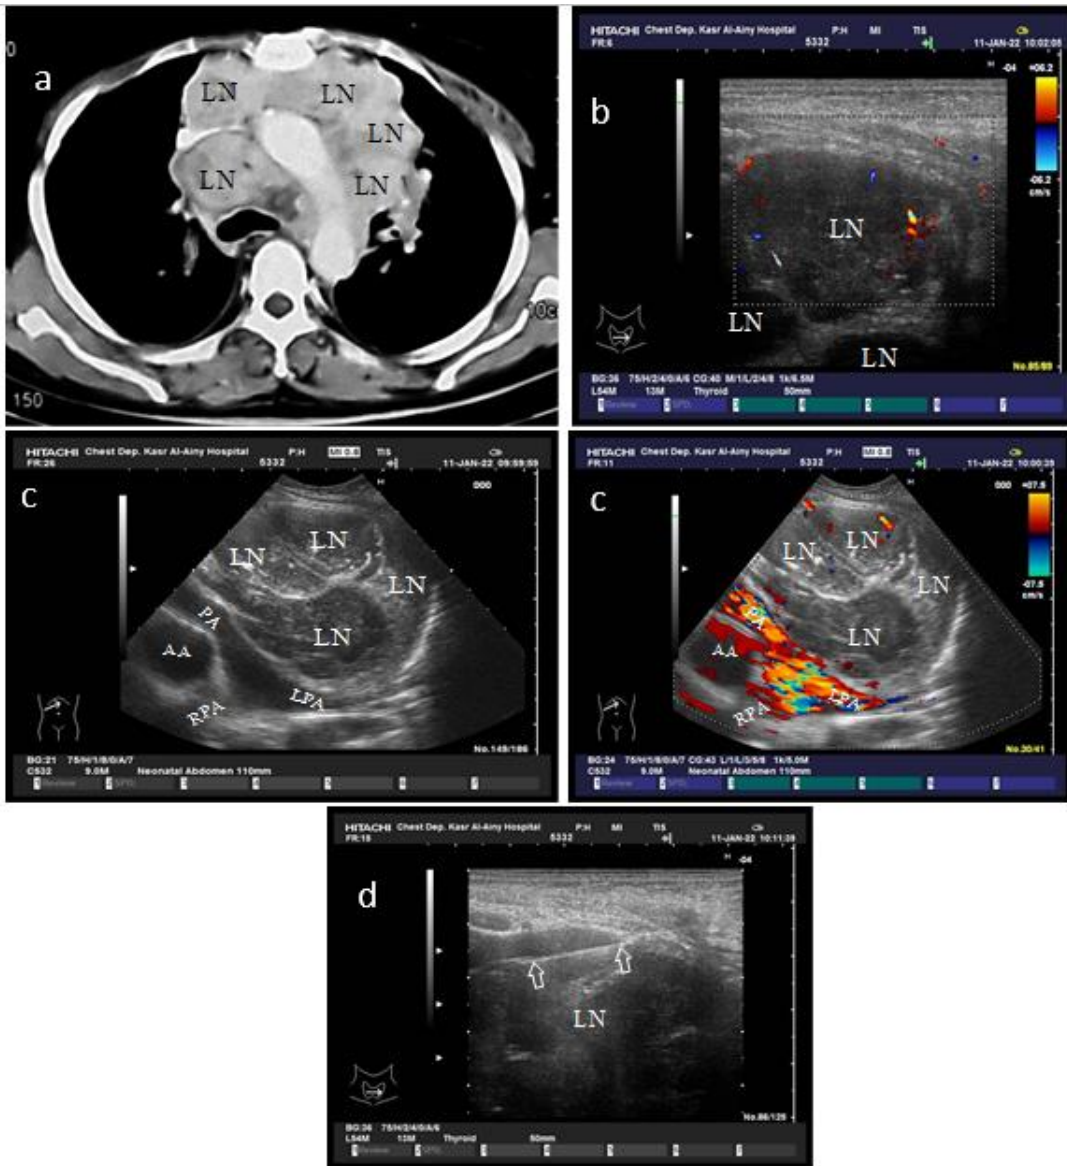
Mediastinal Group, Non-malignant case (TB) (a)CT: Multiple mediastinal LNs(b):US, Doppler, multiple mediastinal LNs(c): Convex probe US, color Doppler, multiple mediastinal LNs with central necrosis and peripheral vasculature(d):Linear probe US, True-cut Needle (white hollow arrows) biopsy from Lt. prevascular mediastinal LN.
